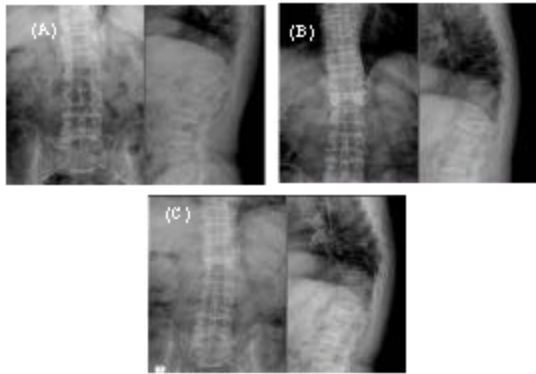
A 65-year-old man with compression fracture on L1, A: Post-trauma radiograph shows 10.5% height loss and 8.5° kyphosis of L1, B: After 3 months-conservative treatment, radiograph shows 28.7% height loss and 17.2° kyphosis of L1, C: 1 year after trauma radiograph shows 34.0% height loss and 22.2° kyphosis of L1
